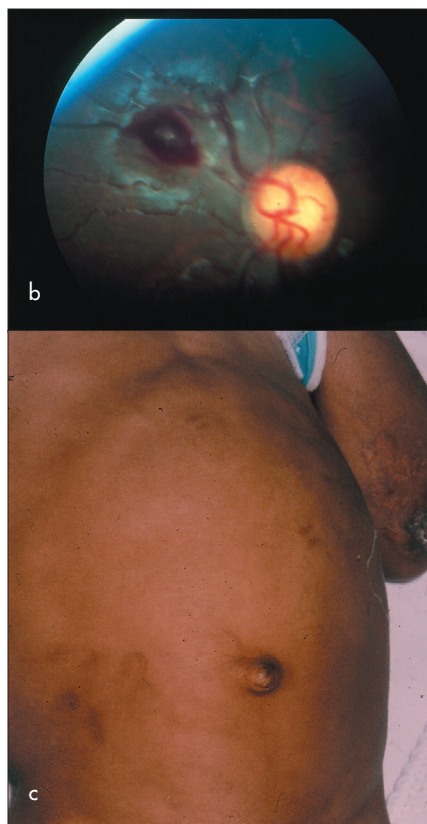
A 4-year-old male was brought to an accident and emergency department in a semi-comatose state by two relatives who gave misleading information about his identity and history. Because of this he was transferred to a paediatric intensive care unit for ventilatory support and further evaluation. Examination confirmed injuries of differing ages and causes including (a) brand marks. Note the impression left by the use of looped cords or chain and the marks left by a straight object, e.g. a stick, as well as old chicken pox scars and scars from cigarette burns. b. A subdural haemorrhage was confirmed by computed tomography (CT) scan and ophthalmological evaluation showed the presence of a retinal haemorrhage. Although he recovered consciousness within 48 hours, he remained pyrexial and developed increasing abdominal distension associated with tenderness to palpation. c. This shows marks suggesting the imprint of an object – possibly the toe of a shoe – in the right iliac fossa and there is clear eversion of the umbilicus. Serum amylase was raised and the diagnosis of a pancreatic pseudocyst was confirmed before laparotomy by ultrasound and CT scans. The child also had an old fracture of the humerus, as well as facial injuries. He made a good clinical recovery but has significant learning difficulties.
